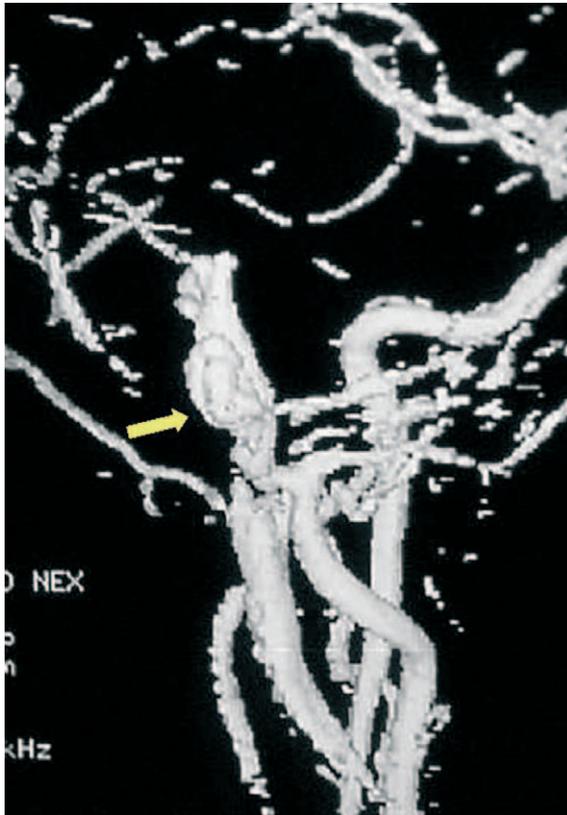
Three-dimensional CT-angiography of the carotid vessels where a vascular lesion in the territory of the external carotid artery can be observed (arrow).
